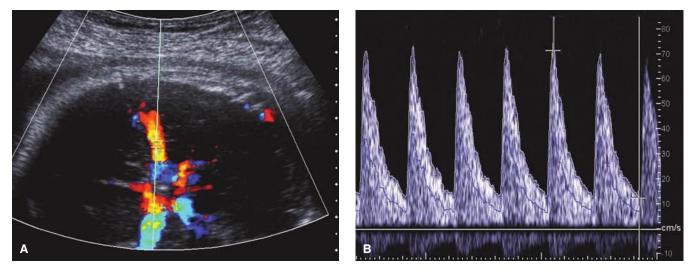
Middle cerebral artery (MCA) Doppler. A. Color Doppler of the circle of Willis demonstrates the correct location to sample the MCA. B. The waveform shows a peak systolic velocity exceeding 70 cm/sec in a 32-week fetus with severe fetal anemia secondary to Rh alloimmunization.
